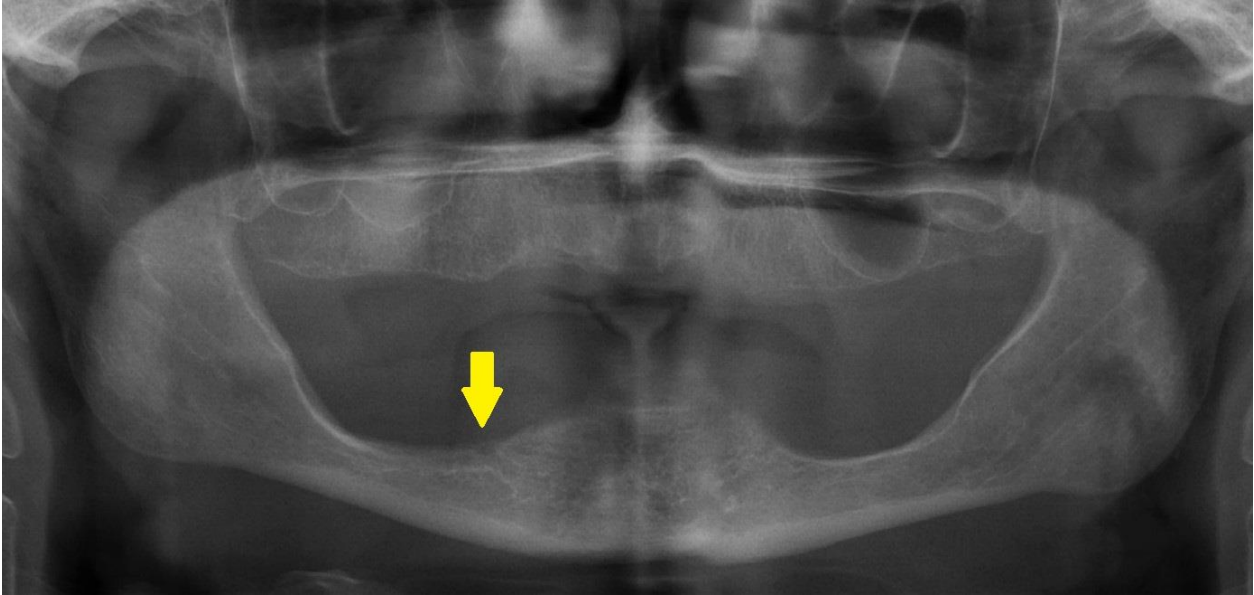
Radiography showing remarkable resorption in the posterior mandible.
